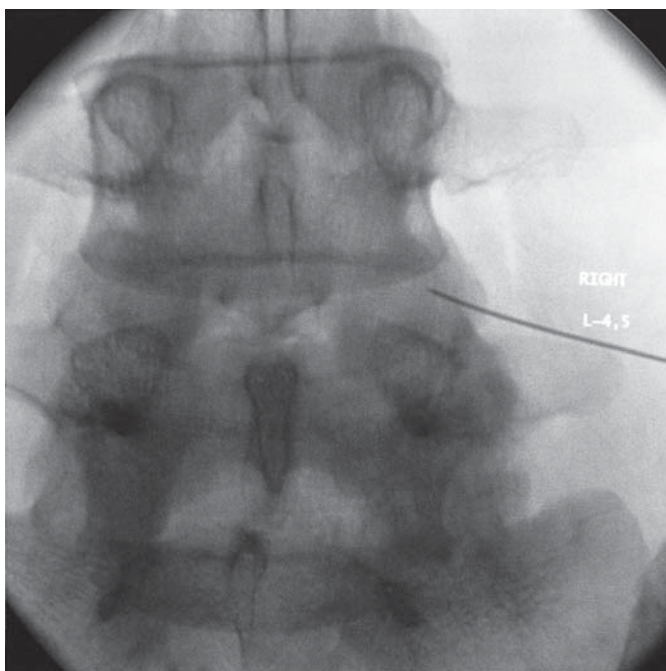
A supine, posteroanterior fluoroscopic radiograph of the correct prearthrographic positioning of the 22-gauge spinal needle in the right L4–5 facet joint.
